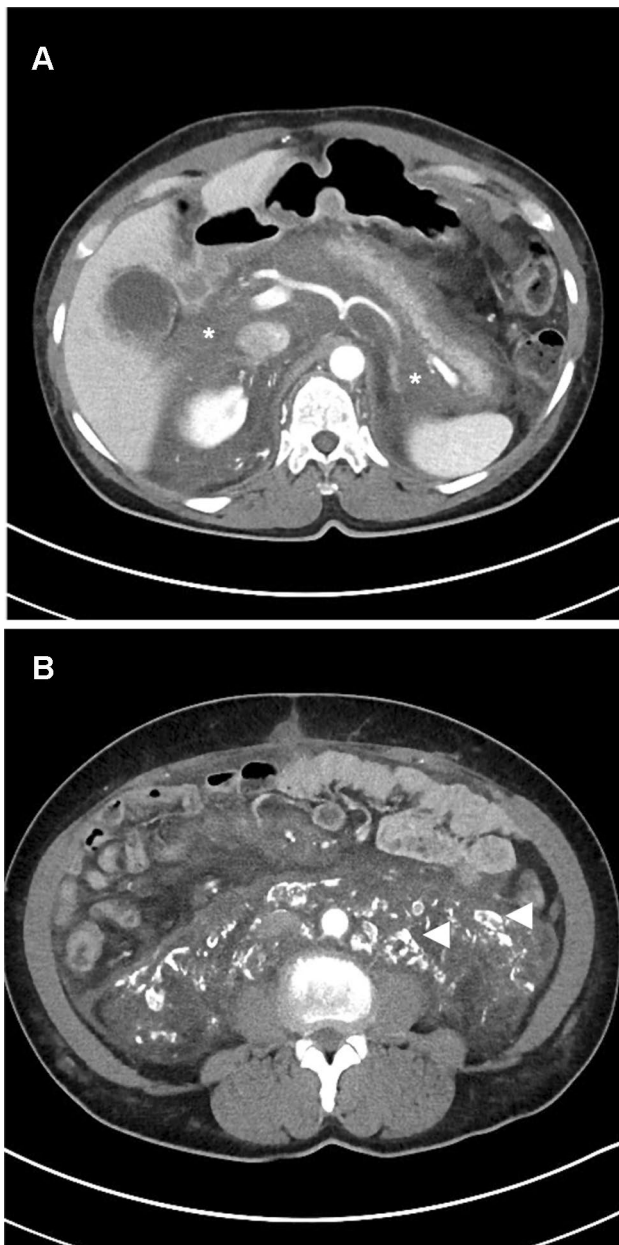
a Retroperitoneal amyloidosis in a 64-year-old man. a Axial contrast-enhanced CT of the abdomen shows infiltrative soft tissue surrounding the aorta and replacing retroperitoneal fat (asterisk). b Axial contrast-enhanced CT shows several coarse calcifications, usually seen in chronic amyloid deposits, throughout the infiltrative soft tissue (arrowheads). b Retroperitoneal amyloidosis in a 64-year-old man. a Axial contrast-enhanced CT of the abdomen shows infiltrative soft tissue surrounding the aorta and replacing retroperitoneal fat (asterisk). b Axial contrast-enhanced CT shows several coarse calcifications, usually seen in chronic amyloid deposits, throughout the infiltrative soft tissue (arrowheads)
